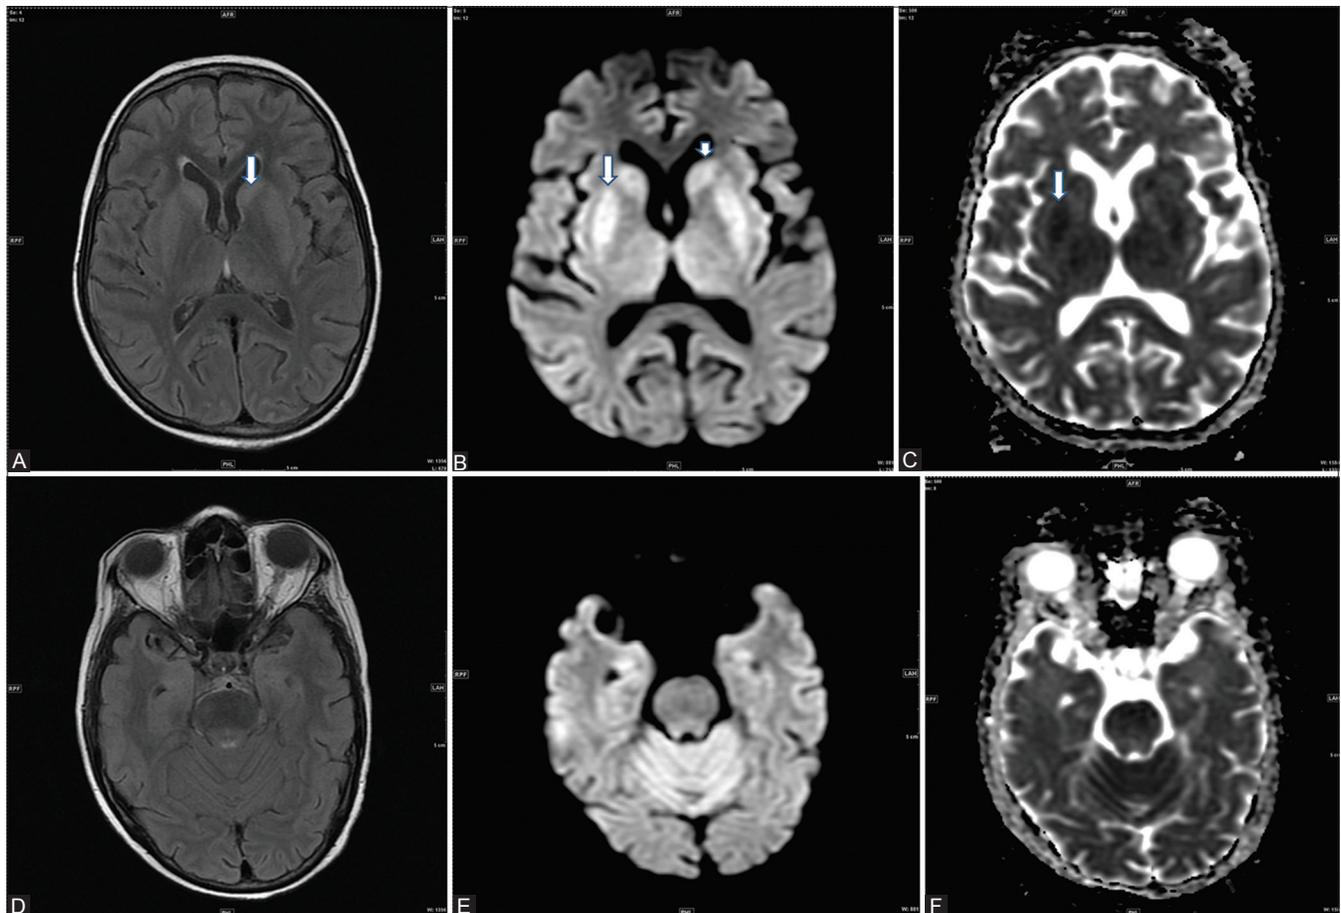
Case 2 (1st MRI - 4 days after correction of hyponatremia) (A) Axial FLAIR section at the level of basal ganglia shows subtle hyperintense signal in both the caudate nuclei and putamina (B) Axial DWI section at the level of basal ganglia shows hyperintense signal in both caudate heads and putamina suggestive of diffusion restriction (C) Axial ADC map at the level of basal ganglia shows low ADC values in both caudate heads and putamina suggestive of extrapontine myelinolysis (D) Axial FLAIR section at the level of pons shows no significant signal change (E) Axial DWI section at the level of pons shows no diffusion restriction (F) Axial ADC map at the level of pons shows no diffusion restriction
